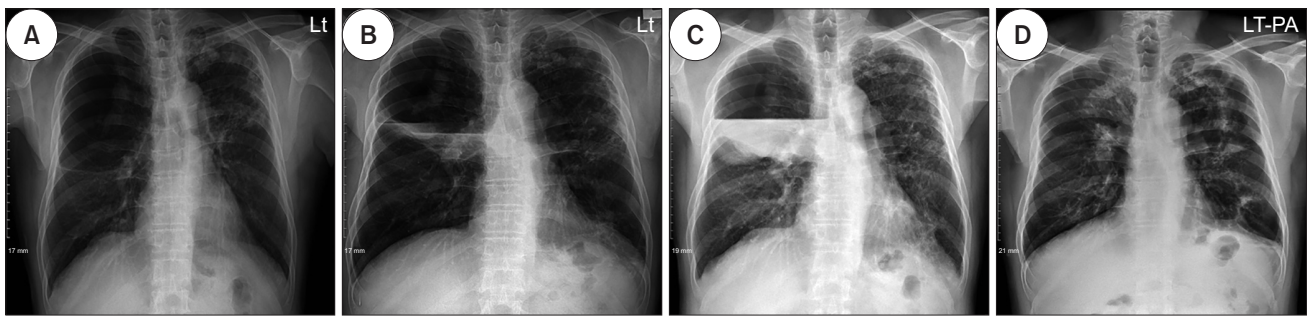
Changes in chest radiographs over time. (A) Two years before admission, a giant bulla occupied more than half of the right upper hemithorax; (B) 9 days before admission, a chest radiograph at another hospital showed an air-fluid level within the bulla; (C) the amount of fluid in the bulla had increased on the chest radiograph taken at admission; and (D) 7 months after diagnosis, there was near-complete resolution of the infectious bulla after tuberculosis treatment. Lt, left; PA, posteroanterior.
